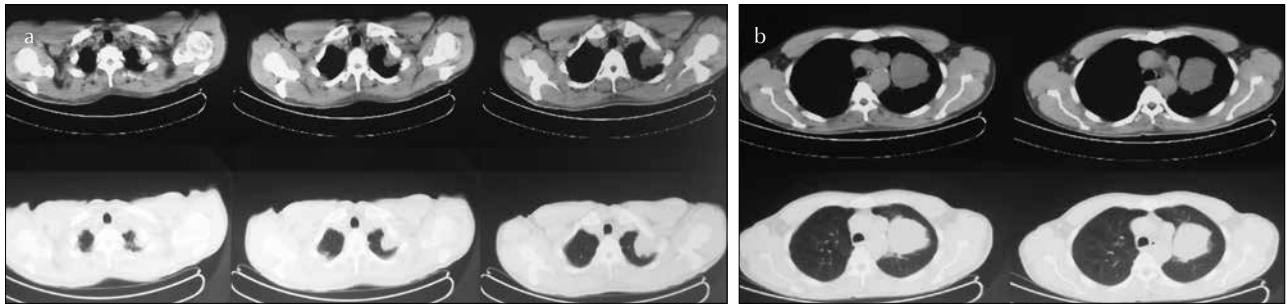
a, b. A chest computed tomography (CT) scan revealed a 75×68×96 mm mass in the left lung. (a) Suspicion of tumor invasion to the first rib. (b) Adjacency of the tumor to mediastinal vascular structures
